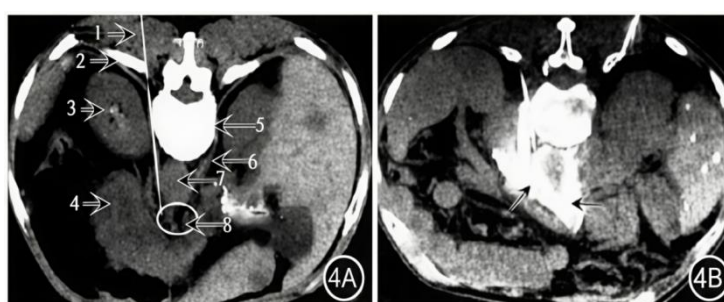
CT guided CPN (T12-L1 level) [17].
